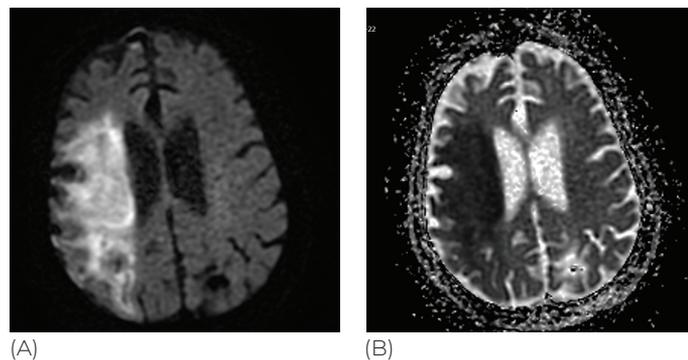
Diffusion image in the same CT section (A) and in the ADC sequences (B). Diffusion reduction was spotted and compatible with acute ischemia in the area fed by the right middle cerebral artery.
